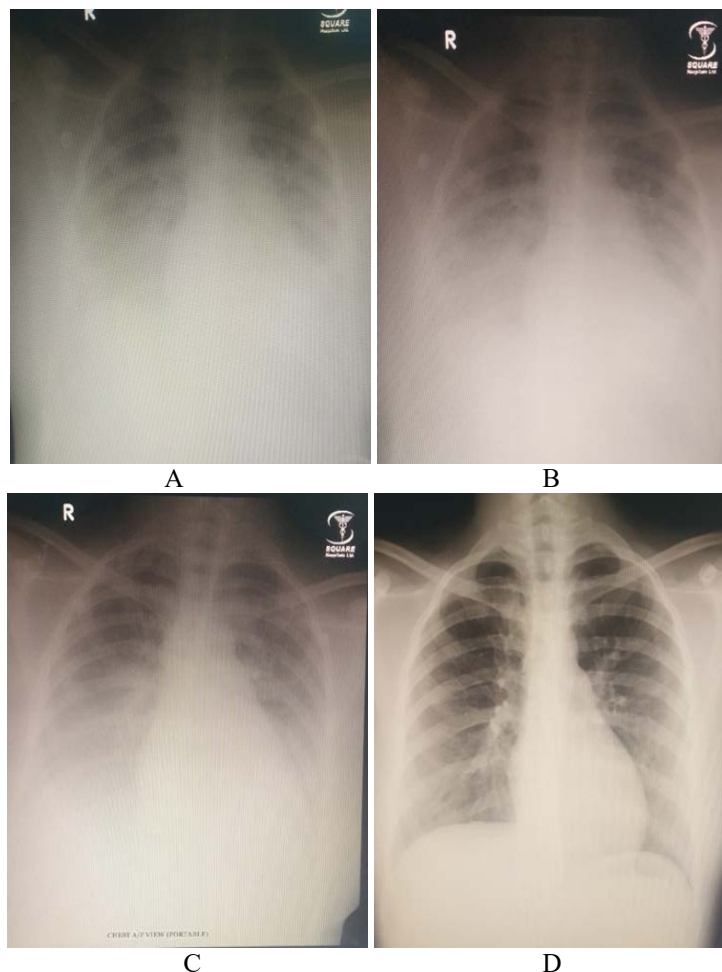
Chest Xray Findings showed haziness in both lower zone, bilateral pleural effusion with cardiomegaly(A),Decreased infiltration on 3rd and 5th day of hospital admission(C,D).CXR P/A view on 14 th day shows complete resolution of opacity (D).
